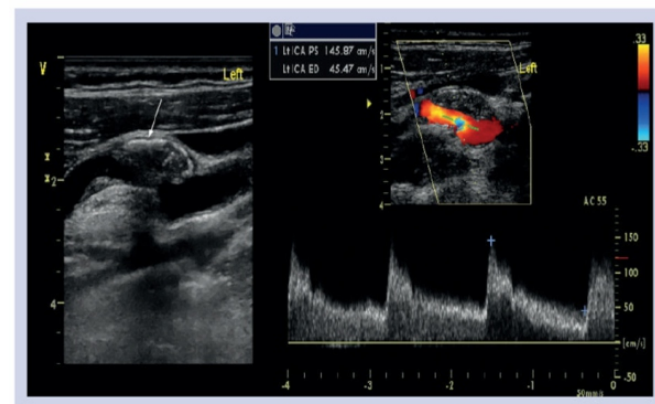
Doppler ultrasound of left carotid artery in a patient with asymptomatic stenosis with suggestive of plaque hemorrhage [9].
